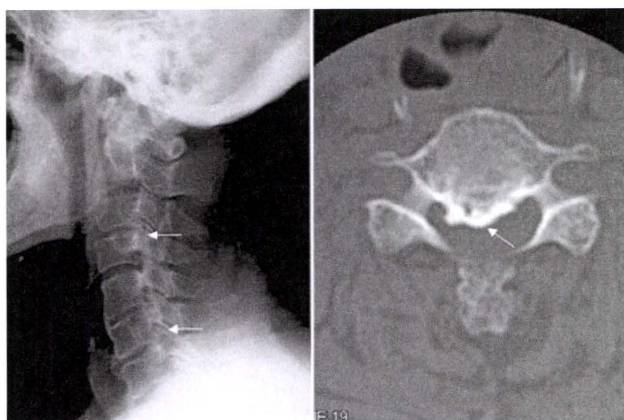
Plain X-ray film of the cervical spine and computed tomography of the younger sister of the dizygotic twins; *white arrows* show ossification of the posterior longitudinal ligament
